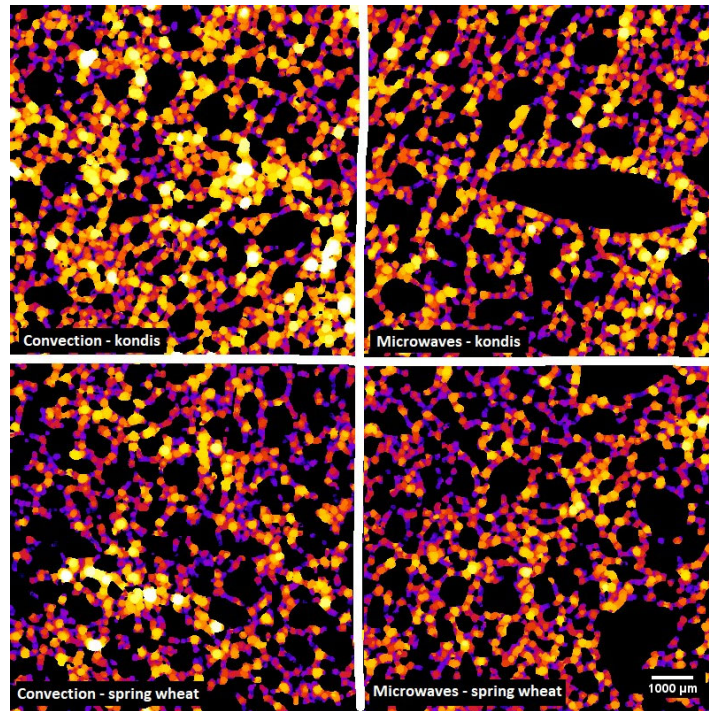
Local thickness of different buns scanned with X-ray microtomography. Warmer colors indicate thicker structures while colder colors indicate thinner structures.
